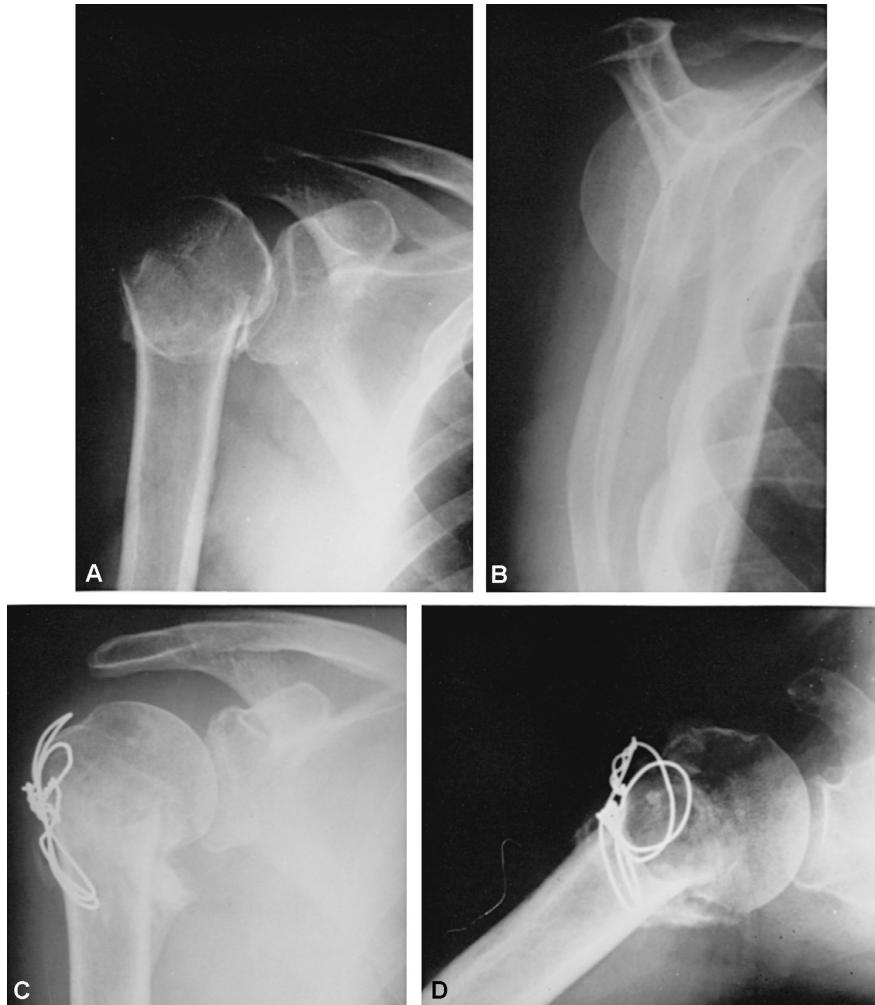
Displaced fracture of the surgical neck. A and B, Anteroposterior and lateral x-ray films of a displaced surgical neck fracture. The fracture was treated for 3 weeks as an undisplaced fracture on the basis of an anteroposterior x-ray film only (A). The follow-up lateral x-ray film (B) in the scapular plane revealed a significant anterior shaft displacement. C and D, Anteroposterior and lateral x-ray films after open reduction and internal fixation with two figure-of-eight wires. (From Rockwood CA, Matsen FA, editors: *The shoulder*; p 353, Philadelphia, 1998, WB Saunders.)
